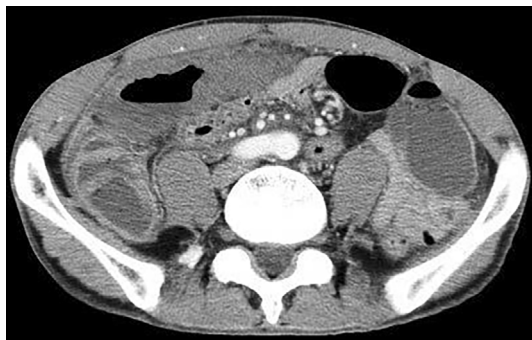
Contrast-enhanced CT revealed thickness of the ascending and transverse colon with decreased enhancement, suggesting necrotic lesions of the colon.
